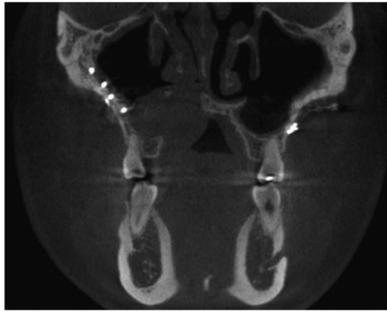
Coronal cone-beam computed tomography showing an extensive, unilocular cystic lesion in the right maxillary alveolus. The floor of the maxillary sinus had been displaced superiorly.
